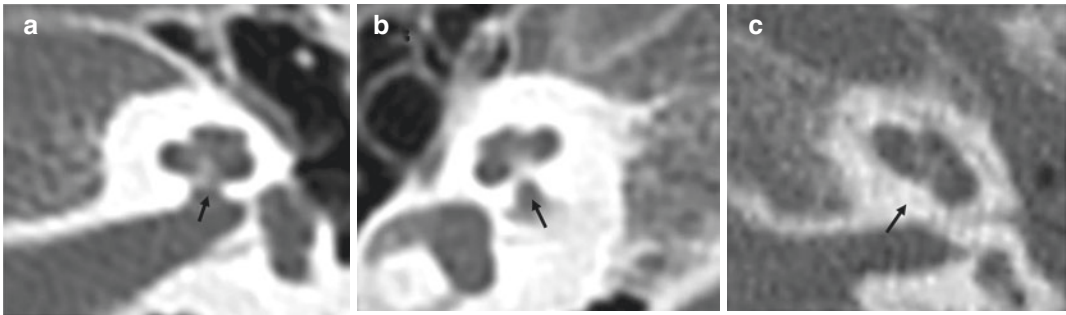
Cochlear aperture. Axial high-resolution computed tomography images showing normal cochlear anatomy with normal cochlear aperture (a) isolated aperture stenosis and (b) isolated aperture atresia (c) (black arrows)
